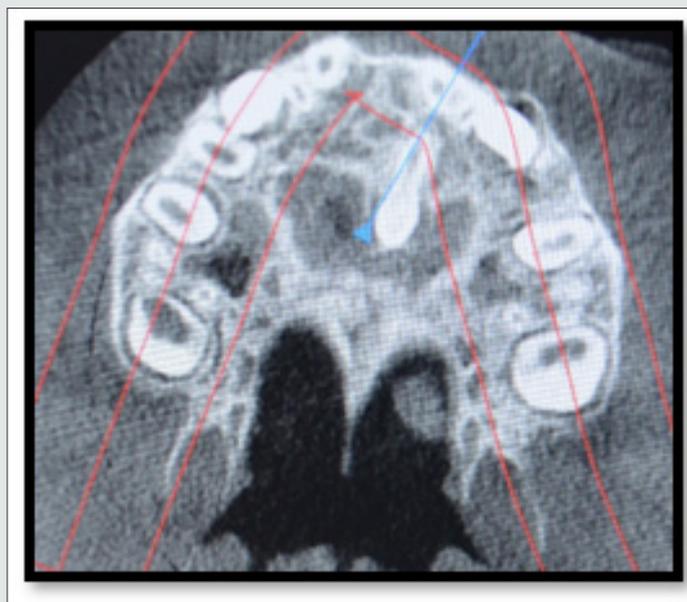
CBCT depicting inverted mesiodens with radiolucency around crown.
